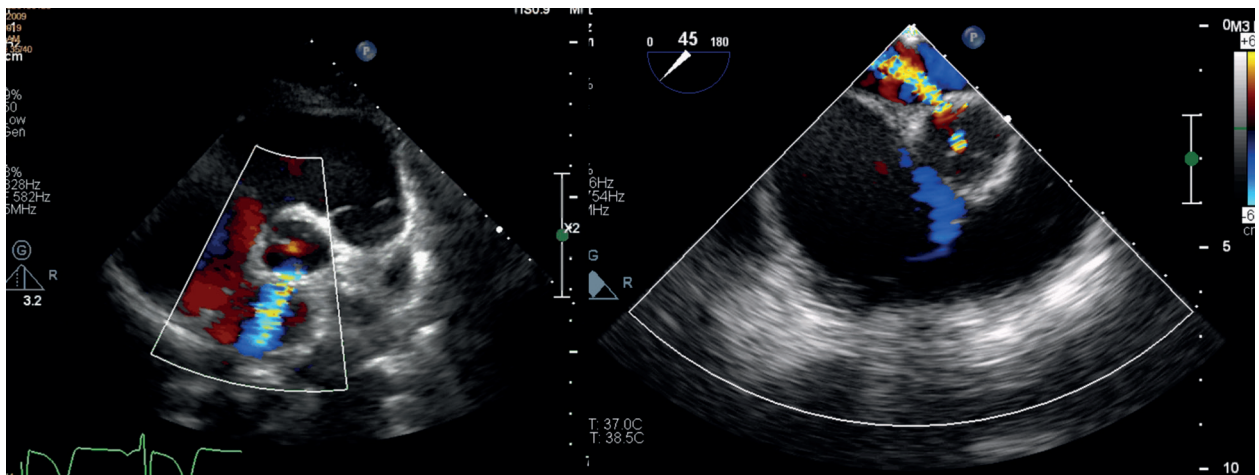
The fistula between the aorta and the left atrium. On the left, transthoracic echocardiography. On the right, the same image in transoesophageal echocardiography
